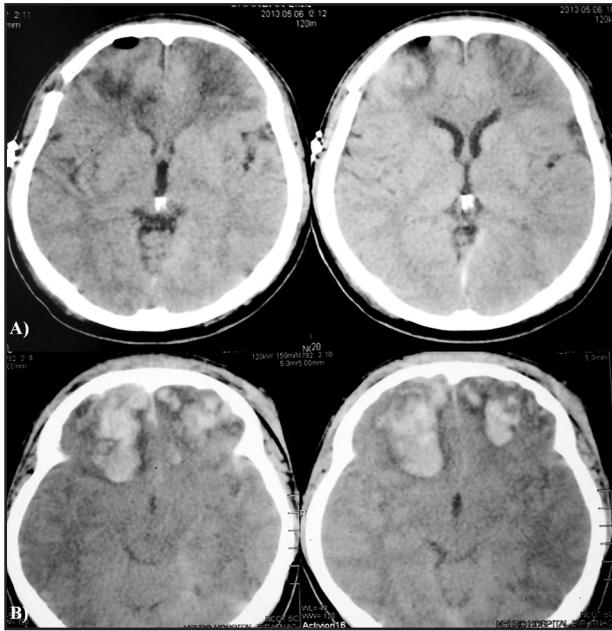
CT head showing bilateral frontal contusion, preoperative (A) and postoperative (B)
